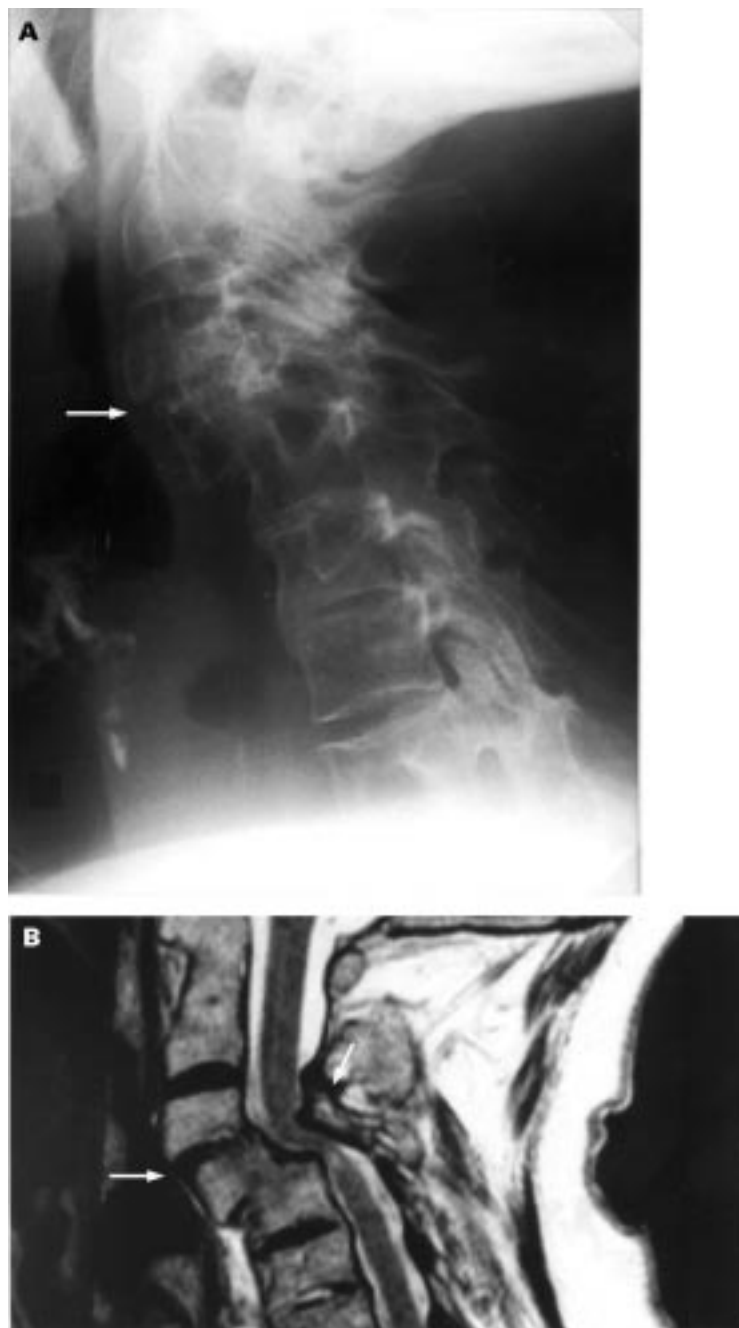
Lateral plain radiography (A) and T2 weighted sagittal MR image (B) of the cervical spine showing reduction and stabilisation of C3–C4 subluxation (3 mm), reduction of compression of the spinal cord, and no changes at C4–C5 level.
